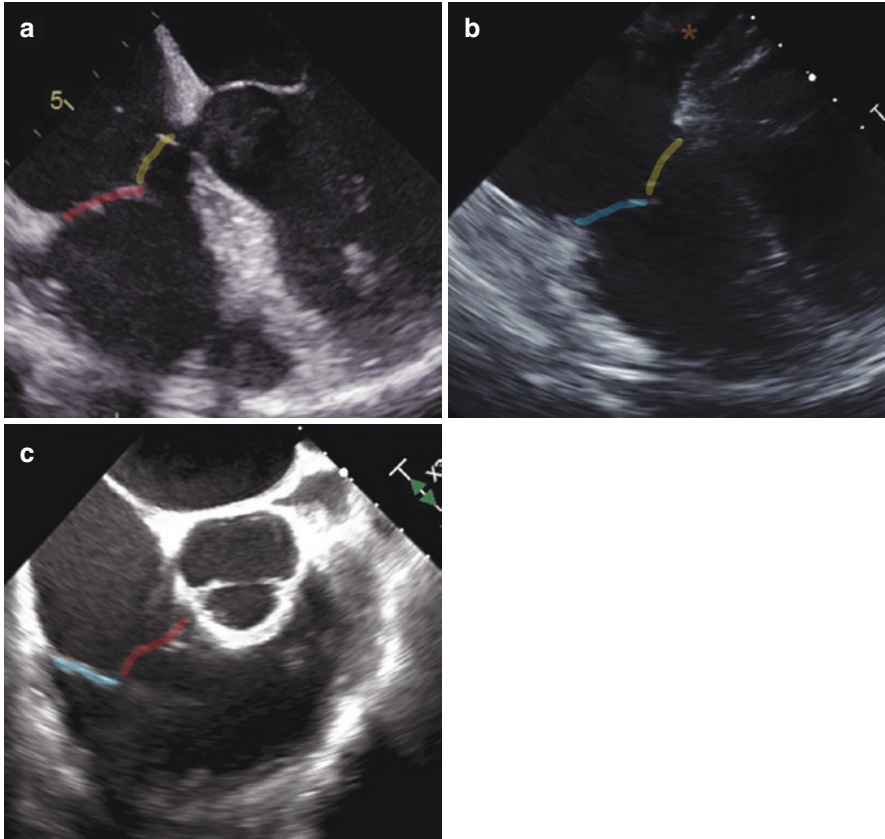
Transesophageal echocardiographic imaging of the tricuspid valve. (a, b) Four-chamber. At 0° , either the septal-anterior leaflets or the septal-posterior leaflets are visualized. Inclusion of the LVOT or aortic valve helps identify the anterior leaflet (a). Inclusion of the coronary sinus (*) helps identify the posterior leaflet (b). (c) $30\text{--}70^\circ$ short axis. Often it is the anterior (red) and posterior (blue) leaflets that are visualized. The septal leaflet is typically not seen in the view; however, use of multiple plane imaging can help identify this leaflet. (d, e) $30\text{--}70^\circ$ short-axis orthogonal views. Orthogonal imaging through the anterior leaflet (d) shows the apposition of the septal (yellow) and anterior (red) leaflets. Orthogonal imaging through the posterior leaflet (e) identifies the apposition of the septal (yellow) and posterior (blue) leaflets. (f) Transgastric short axis. This 2D TEE view identifies all three leaflets en face simultaneously: anterior (red), septal (yellow), and posterior (blue). (g, h) Transgastric orthogonal views. Orthogonal imaging through the anterior leaflet (g) shows the apposition of the anterior (red) and posterior (blue) leaflets. Orthogonal imaging through the septal leaflet (h) identifies the apposition of the septal (yellow) and posterior (blue) leaflets. (i) Deep transgastric. In the deep transgastric view, often the septal (yellow) and anterior (red) leaflets are seen, given that this view is obtained with antelexion when the aortic valve is in view. (j, k) Deep transgastric orthogonal views. Orthogonal imaging through the septal leaflet (j) shows the apposition of the septal (yellow) and posterior (blue) leaflets. Orthogonal imaging through the anterior leaflet (k) identifies the apposition of the anterior (red) and posterior (blue) leaflets
